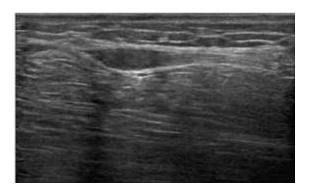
Ultrasound of forearm swelling
